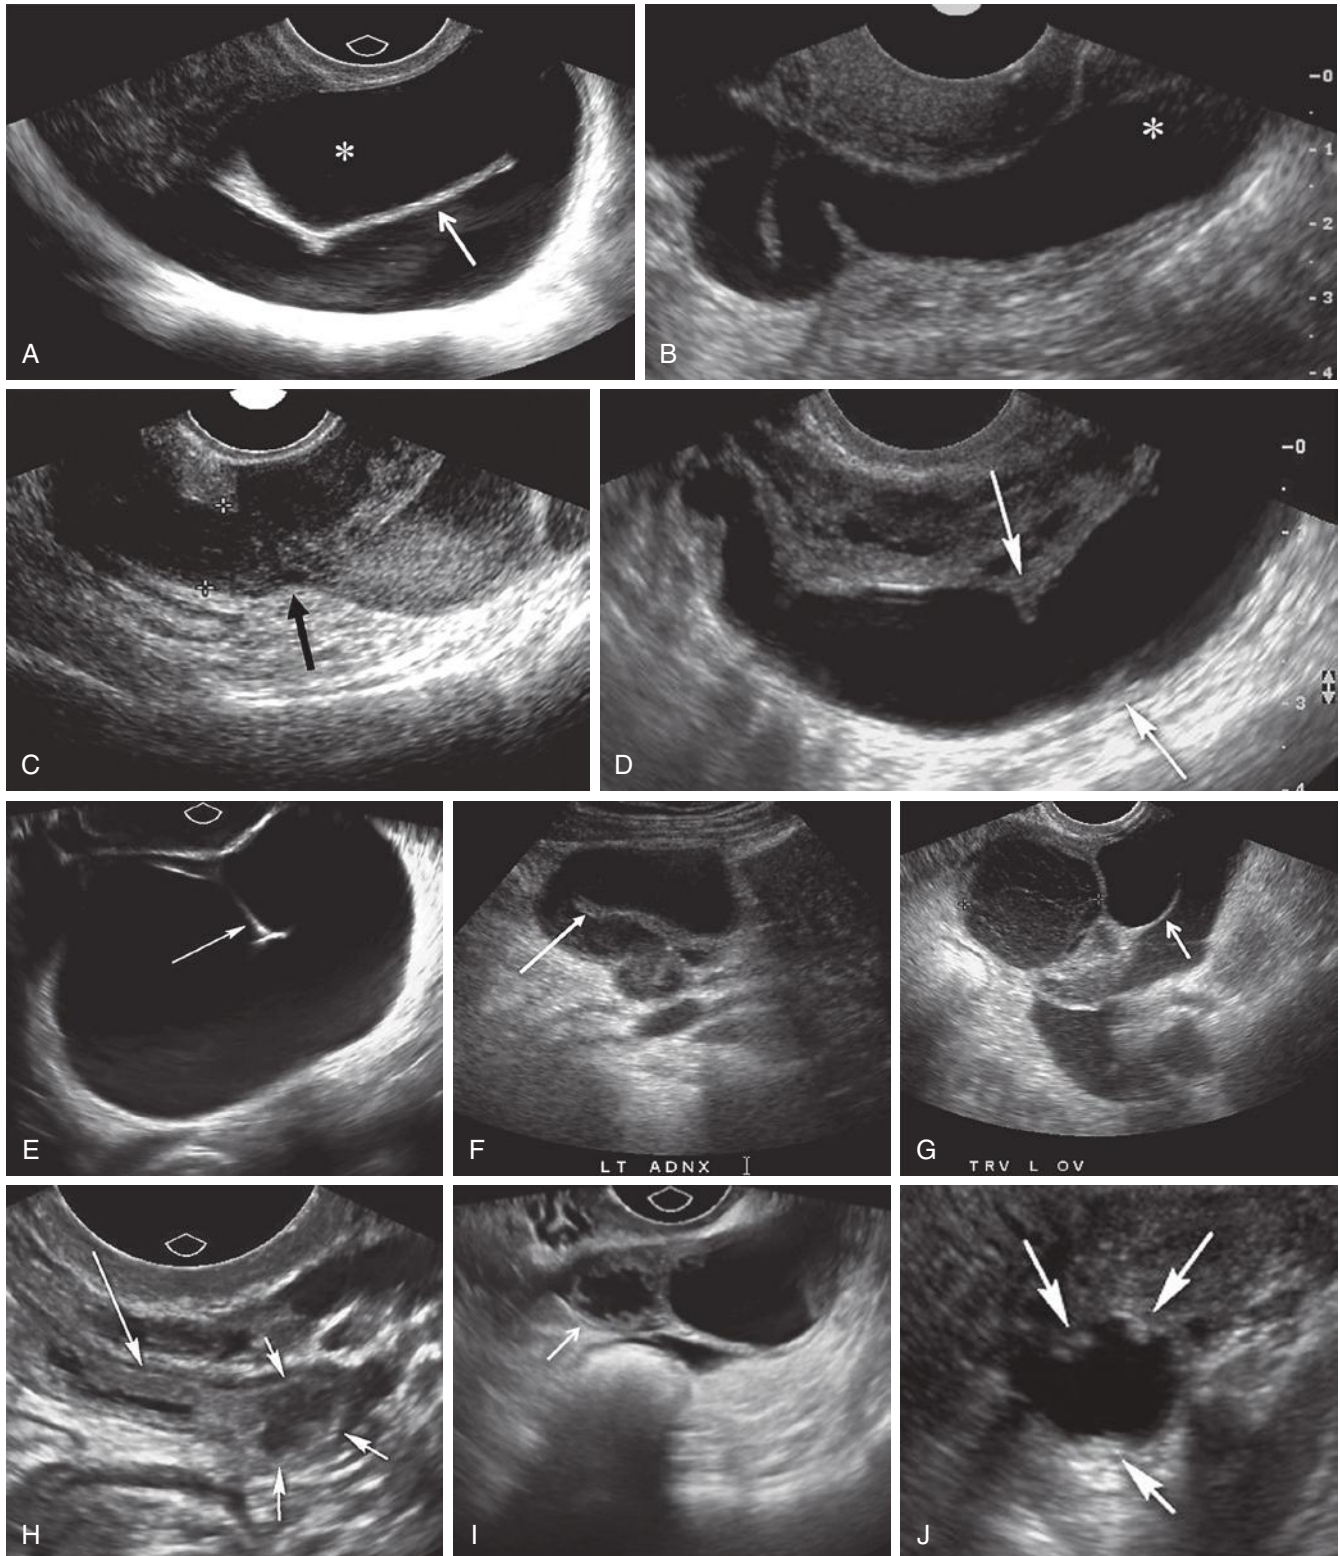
The varied ultrasound image appearance of hydrosalpinx. A, Dilated anechoic tubular left adnexal structure in a U shape is consistent with hydrosalpinx. Note that the ampullary end (*asterisk*) anteriorly is wider than the isthmic portion of the tube, which is more posterior on this image. The linear echogenic structure (*arrow*) between the ampullary and isthmic segments represents the two juxtaposed inner walls of the tube as it folds on itself and has been described as the “incomplete septation sign.” Unlike a true septation, the incomplete septation of a folded tube will not extend from wall to wall and the lumen of the tube will remain open around the free edge. This sign helps to differentiate a folded hydrosalpinx from a complex, cystic adnexal mass. B, Serpiginous or S-shaped hydrosalpinx. The more lateral ampullary end
